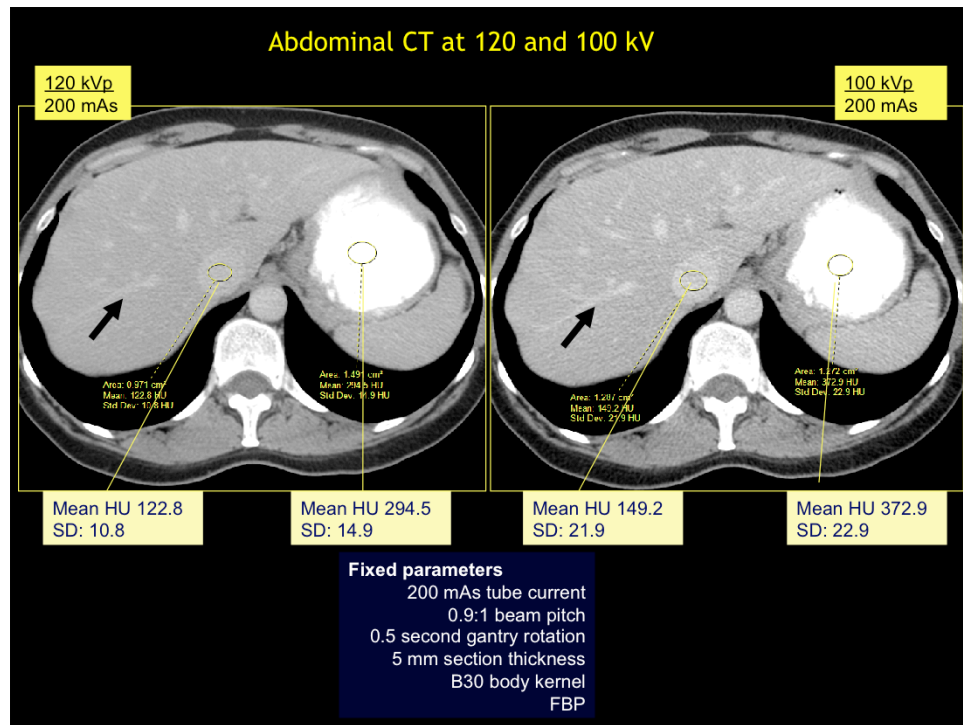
Contrast enhanced abdominal CT performed at varying kV of 120 and 100. Lower kV results in increased image noise in hepatic parenchyma but also allows better visibility of hepatic vessels. For arterial phase imaging of the abdominal structures, low kV (80-100kV) should be applied in at least small to medium size patients in order to improve the image contrast and reduce radiation dose. In larger patients, 120 kV may be more suitable for abdominal imaging in arterial phase.
